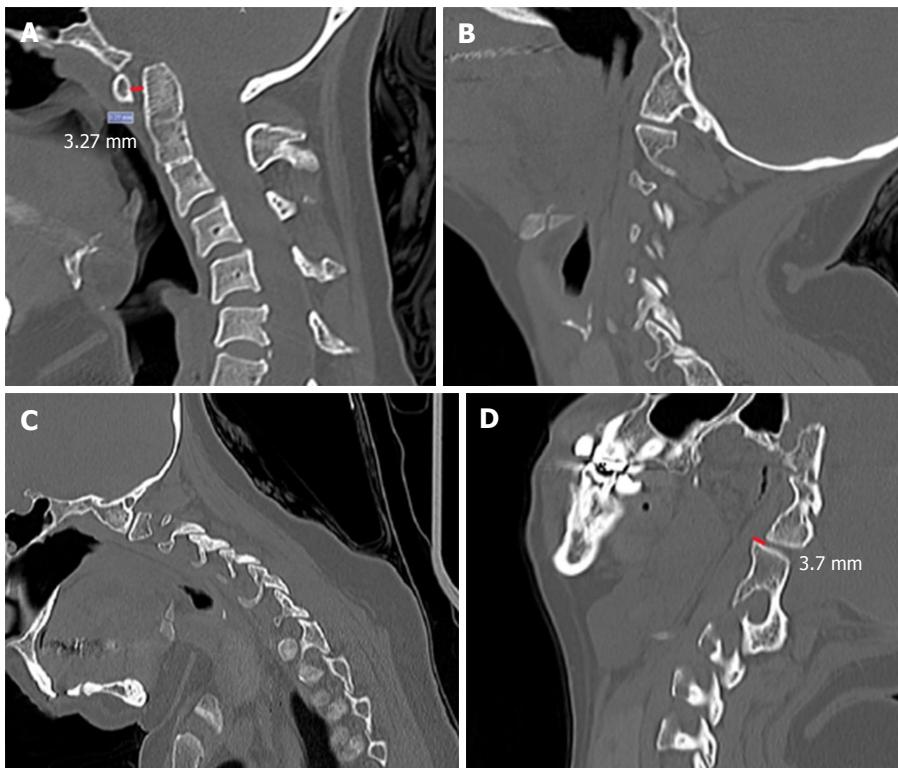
Forty-year-old woman with a tonsilar herniation of 5 mm and basilar invagination. Noted that she also had atlas assimilation and a congenital C2 fusion A, B and C: Pre-operative dynamic imaging, showing a atlanto-dental interval of 3.27 mm, but no signs of facet dislocation in flexion or in extension (B and C); D: Sagittal computed tomography scan obtained after some months after posterior fossa decompression showing an evident facet joints dislocation (the assimilated lateral mass of C1 was dislocated posteriorly over the superior facet joint of C2). She had some symptoms of dizziness and cervical pain when flexing the neck and an occipito-cervical fixation was proposed but the patient declined surgical treatment because she was not doing well with depression and mood disorders.
